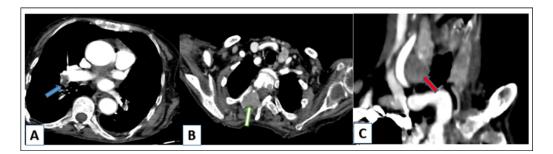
Chest CT angiography showing a right lower lobar pulmonary embolism (A), with irregular osteolytic lesion located at the level of D3 with endocanalar extension (B), a lesion opposite the lower pole of the right thyroid lobe, hypodense, related to the parathyroid adenoma (C).
